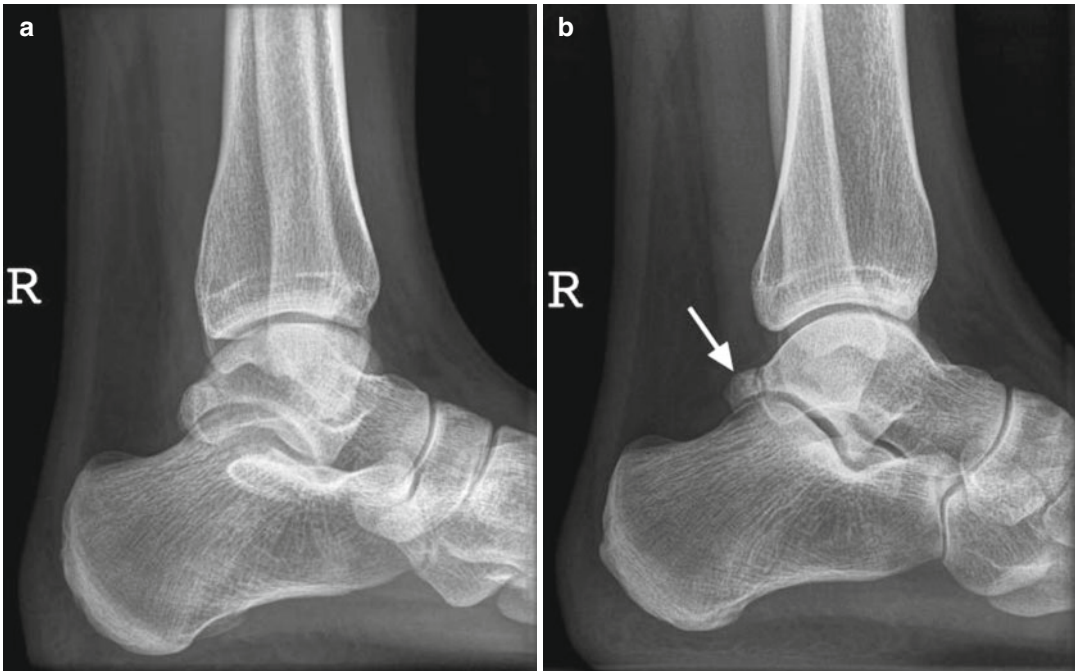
A 22 year-old female volleyball player with posterior impingement complaints: standard lateral X-ray (a) showed no abnormality. The PIM view (b), clearly shows an os trigonum (arrow)
